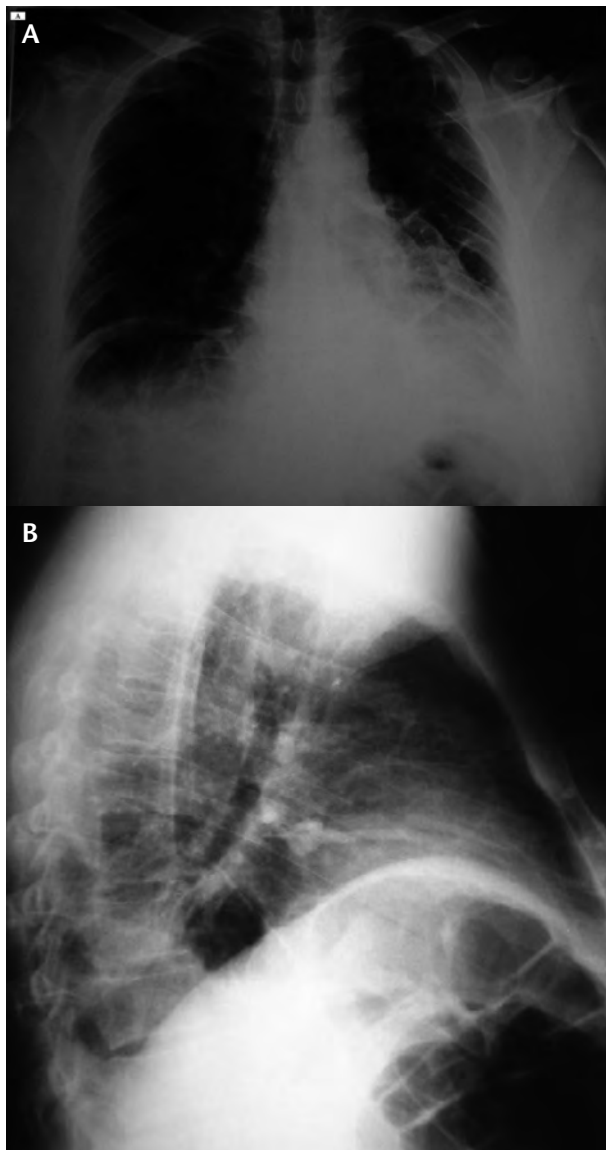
Chest X-ray: A) Note the right subdiaphragmatic air and right rib fractures and left pleural effusion. B) Lateral view in which the haustral folds were identified.
